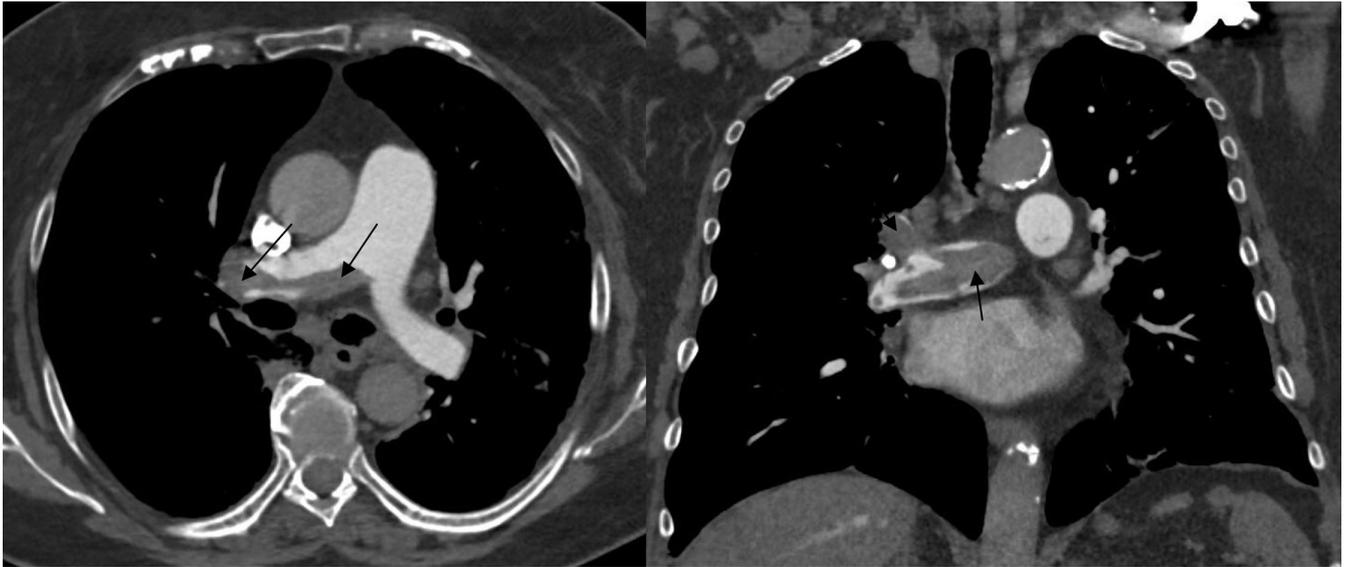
Pulmonary computed tomography angiography (CTA). Loss of pulmonary artery filling (arrows) during acute pulmonary embolism
